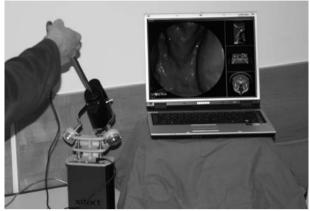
When flying through the nose, the actual position in the 3 body axes is shown on the CT image in order to receive a better view in "blind" regions and thus support the surgeon.
